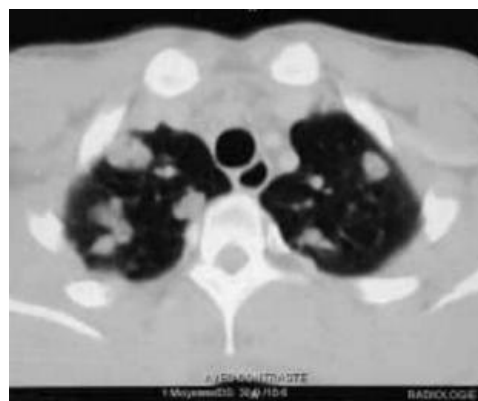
Chest CT scan. Multiple nodular opacities and bilateral cystic formations
